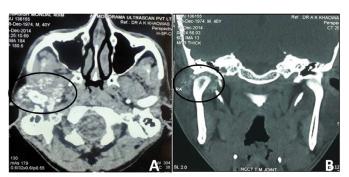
CT-A. Axial view. B. Coronal view.
